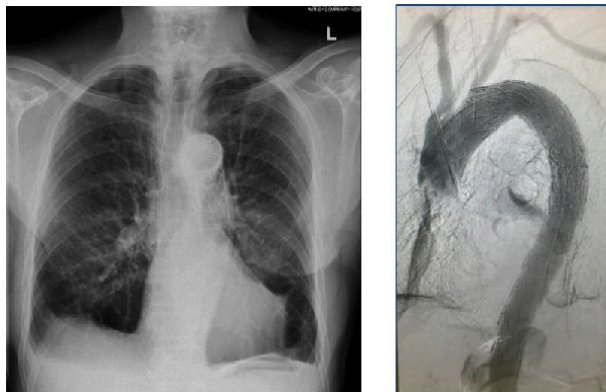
A CXR (left) and CTA (right) showing the stent graft thoracic aorta used to manage type B aortic dissection. The graft was placed on the left subclavian origin.
